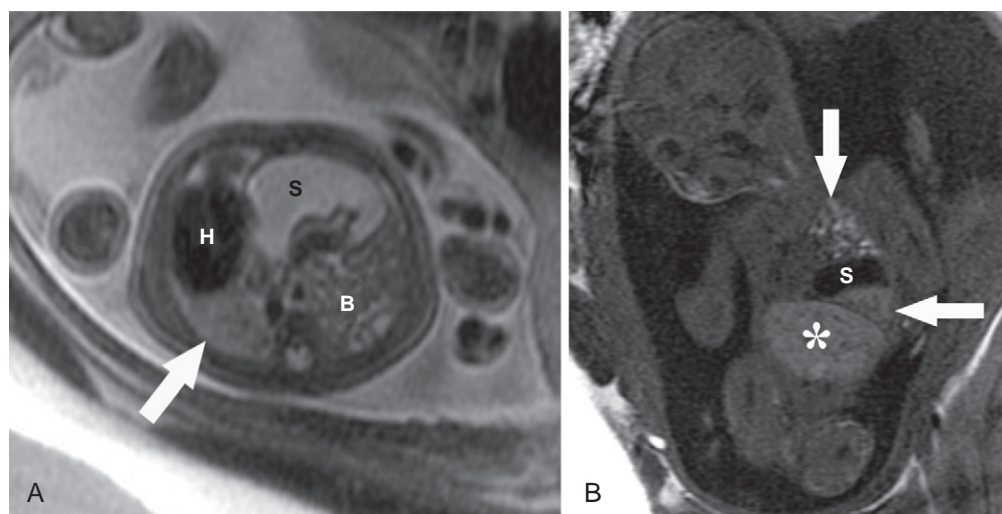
A, Axial ssFSE T2-weighted image of a fetus at 24 weeks' gestation with a left-sided congenital diaphragmatic hernia (CDH). The heart (H) and right lung (arrow) are displaced to the right. The left lung is not visible, and instead the left side of the chest contains herniated stomach (S) and bowel (B). B, Sagittal spoiled gradient-echo T1-weighted magnetic resonance image shows the stomach (S) in the left side of the chest. Note the liver (asterisk) is of relatively high signal intensity, facilitating the identification of the herniated left lobe (horizontal arrow) in the left side of the chest. The herniated bowel loops (vertical arrow) in the left side of the chest are also of relatively high signal intensity.
